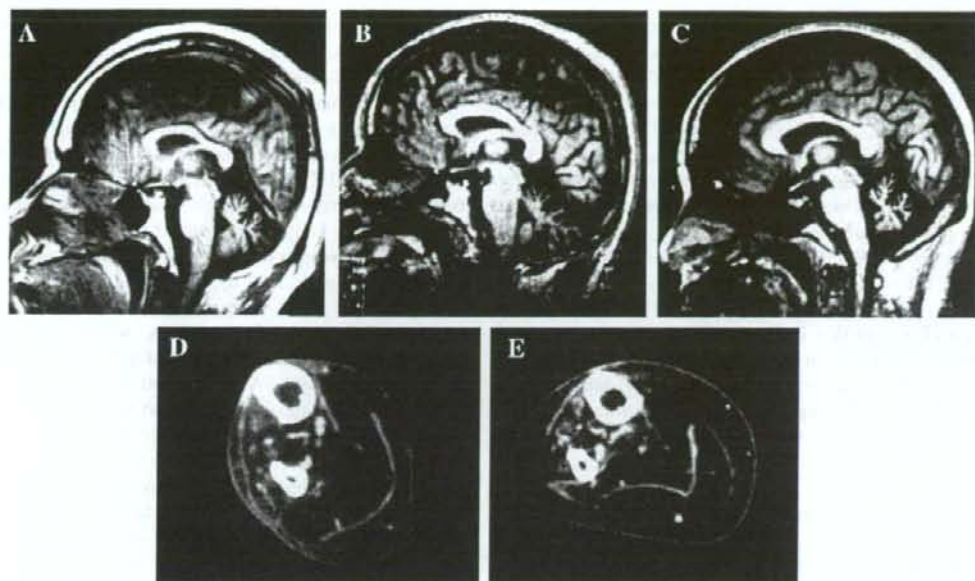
Brain magnetic resonance imaging (MRI) and muscle computed tomography (CT) images. A–C: Sagittal planes of T1-weighted MRI images in patients IV-3 (A), IV-4 (B), and IV-6 (C). All images show marked atrophy of the cerebellar vermis. D, E: CT scans of calf muscles in patients IV-3 (D) and IV-6 (E). The low-density appearance of the muscles indicates fatty degeneration.
